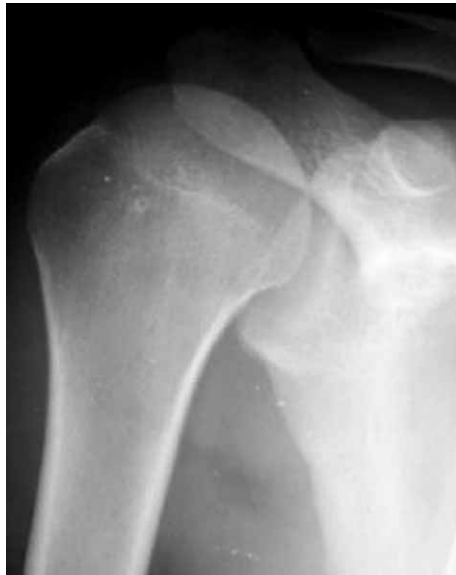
Standard x-ray of the right shoulder reveals normal radiographic structure of the proximal humerus.
